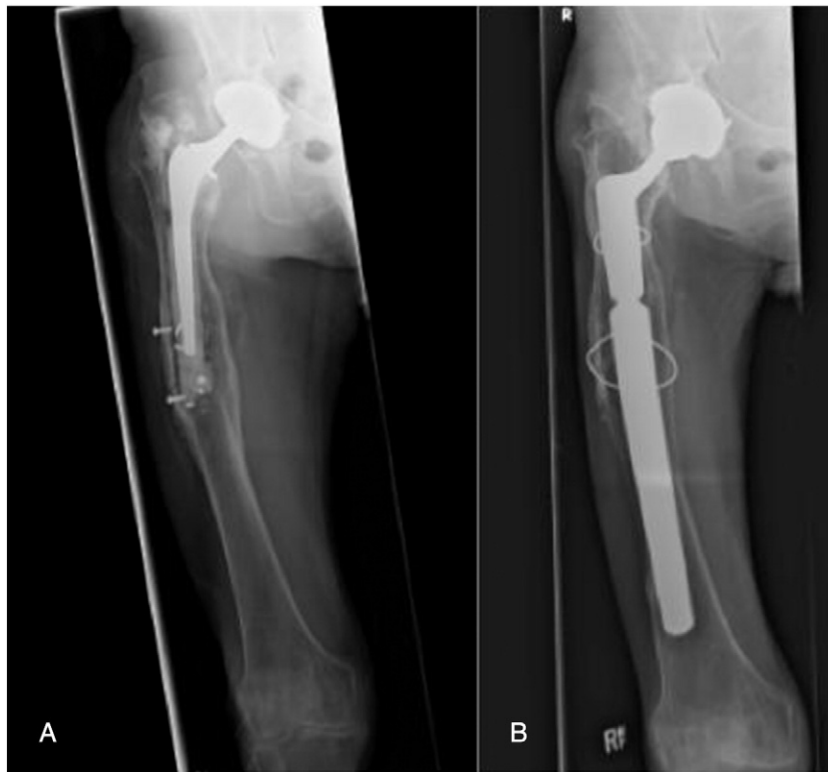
Preoperative (A) and postoperative (B) full length femur radiographs for a patient undergoing revision for aseptic loosening with the Restoration Modular Stem.
